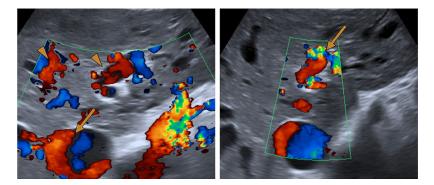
Ultrasound images with color Doppler depicts several tubular structures paralleling the intrahepatic portal branches representing dilated arterial branches (arrowheads) as well as markedly dilated and tortuous intrahepatic vessels suggestive of arterioportal shunts (arrows).
